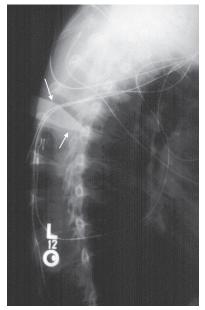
Chest x-ray (lateral view). WA = retained knife in the back
